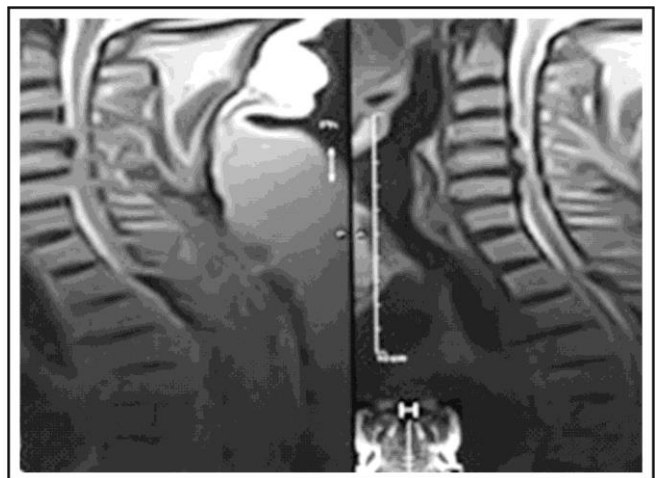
MRI image of two levels of disc prolapse C4 – C5 and C5 – C6 (Used with patient's permission).
